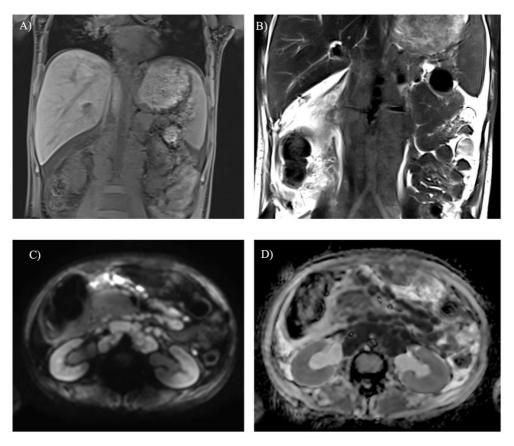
A) Coronal T1 vibe Dixon water-only image and B) STIR image showing iso-intense retroperitoneal lymph nodal mass in biopsy-proven case of DLBCL. Ascites and subcutaneous oedema are also seen. C) & D) DWI & ADC map images of enlarged retroperitoneal & mesenteric nodes showing diffusion restriction.
